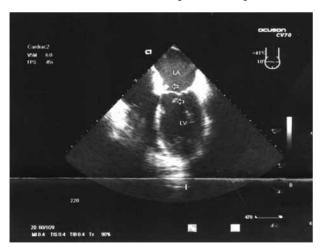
Transesophageal ultrasound: mitral valve with floating vegetation at the top of the atrial side of the anterior mitral leaflet, with a thread-like formation on the edge of the same leaflet in the space of the left ventricle.
